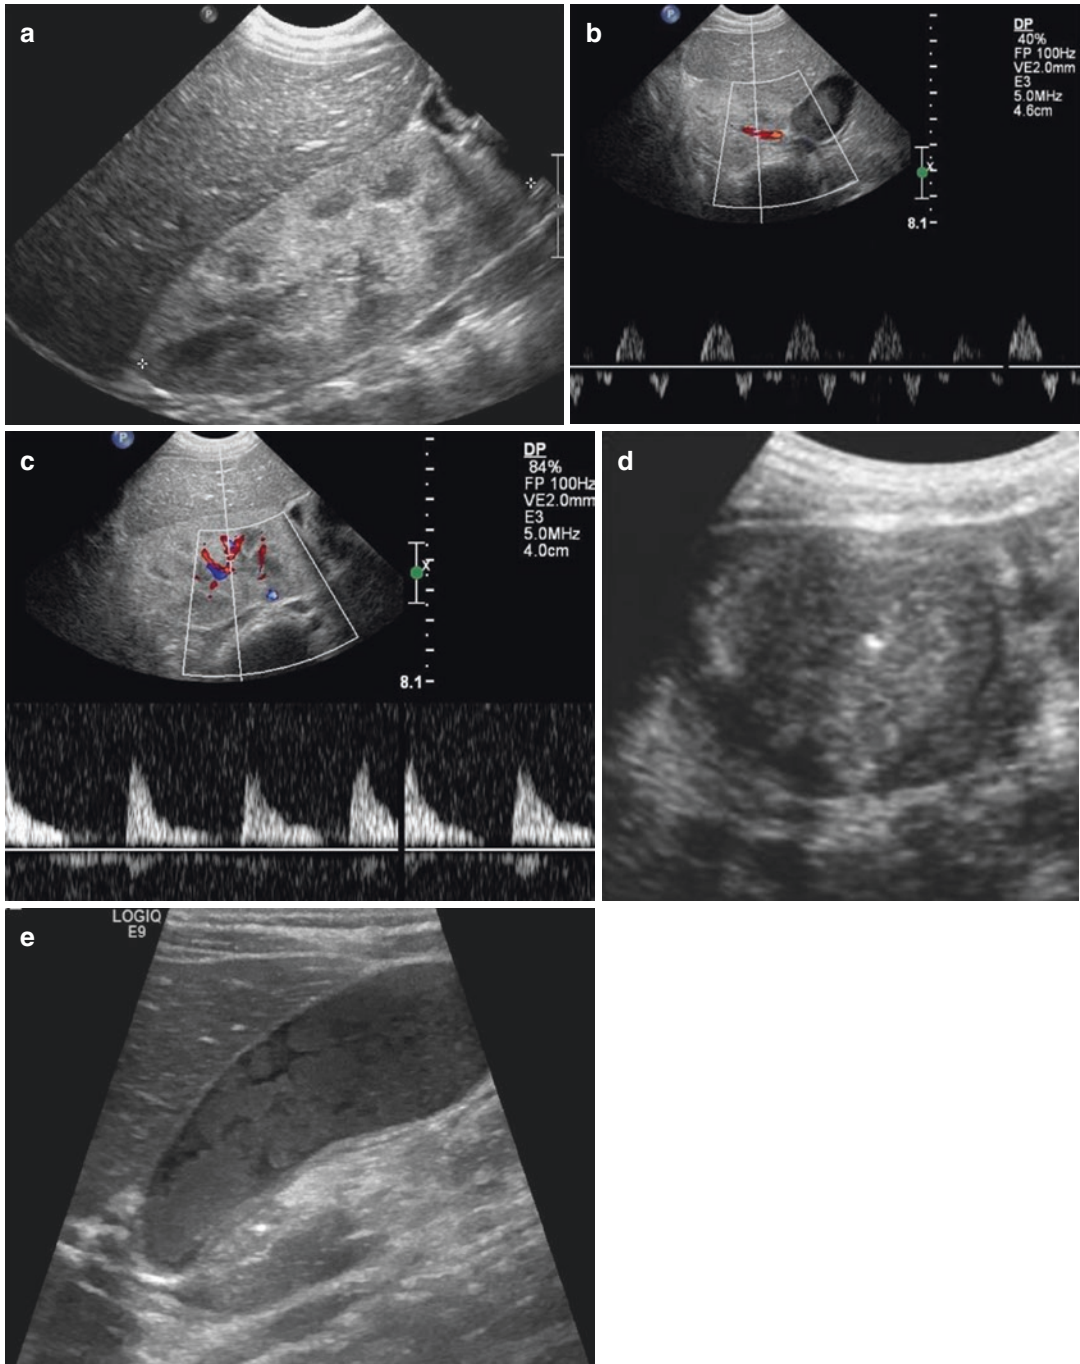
Hemolytic and uremic syndrome (HUS)—US findings. (a) Examination obtained during the anuric/acute stage—Sagittal scan of the kidney (similar to the left one). The kidney is normal sized. The cortex appears hyper-echoic with preserved CMD. (b) Duplex Doppler obtained during the acute stage. The spectrum demonstrates lack of normal diastolic flow. (c) Duplex Doppler obtained during
